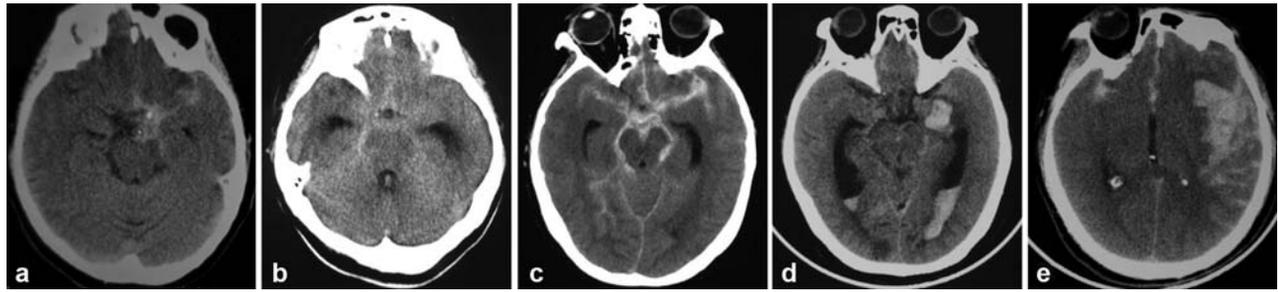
Axial computed tomography scans showing the different degrees of subarachnoid hemorrhage (SAH) caused by rupture of an anterior choroidal artery aneurysm. (a) Type 1: SAH confined to the ipsilateral crural cistern. (b) Type 2: small amount of blood clot in the bilateral Sylvian cistern and suprasellar cistern. (c) Type 3: moderate hematoma in the bilateral Sylvian cistern and suprasellar cistern (►Fig. 1c); type 4: more than a moderate amount of hematoma in the bilateral Sylvian cistern and suprasellar cistern, accompanied by intraventricular hemorrhage (►Fig. 1d); and type 5: ipsilateral temporal pole hematoma (►Fig. 1e). Seven patients showed no SAH, referred to as type 0. Digital subtraction angiography (DSA) or computed tomography angiography (CTA) examination confirmed an AChAA.
